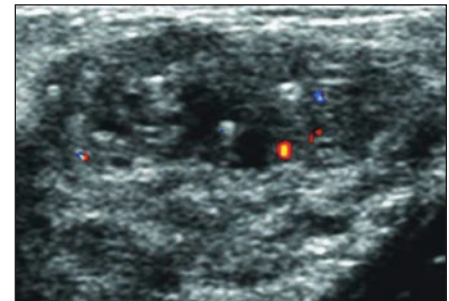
16-year-old girl with palpable breast mass. Sonogram shows minimally vascular 2.5-cm well-defined ellipsoid hypoechoic mass containing tiny cystic components associated with comet tail artifacts. Excisional biopsy revealed sclerosing lobular hyperplasia.
